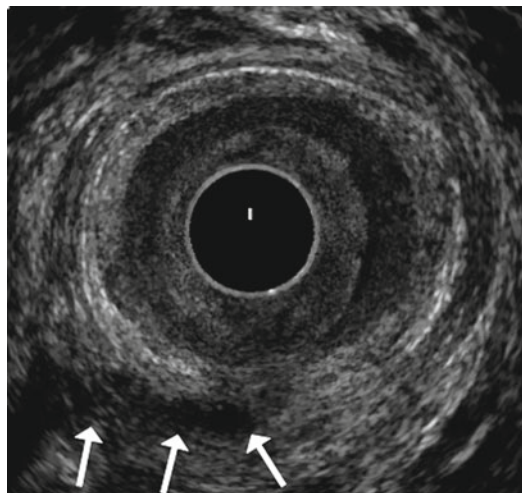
Anal endosonography of a man with a transsphincteric fistula (same patient as Fig. 18.4). There is a hyporeflexive track (*arrows*) through the external sphincter, but it is more difficult to appreciate that this is due to a transsphincteric fistula than on the corresponding MR image unless the sonographer is very experienced
